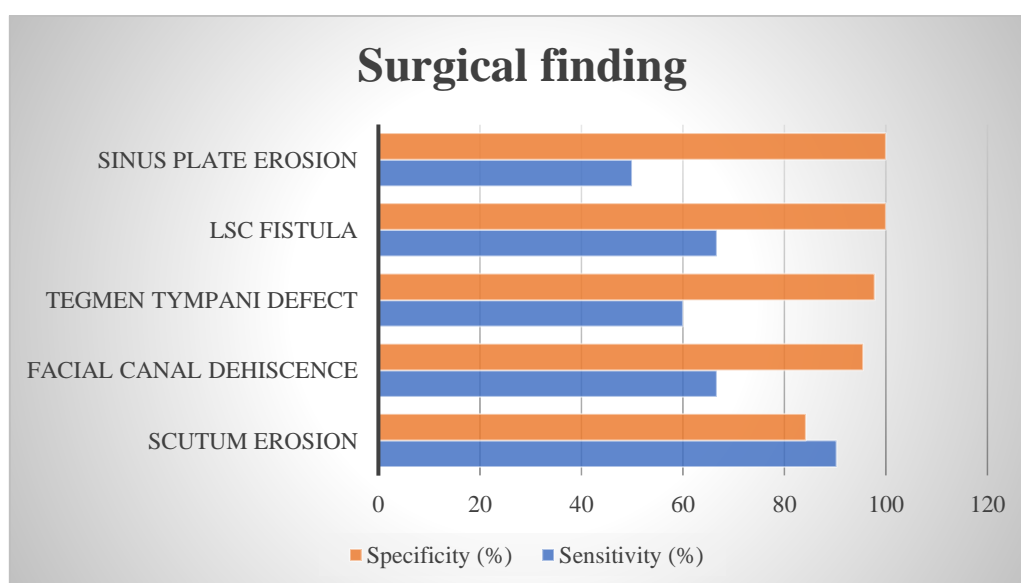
HRCT Diagnostic Accuracy for Additional Surgical Findings
